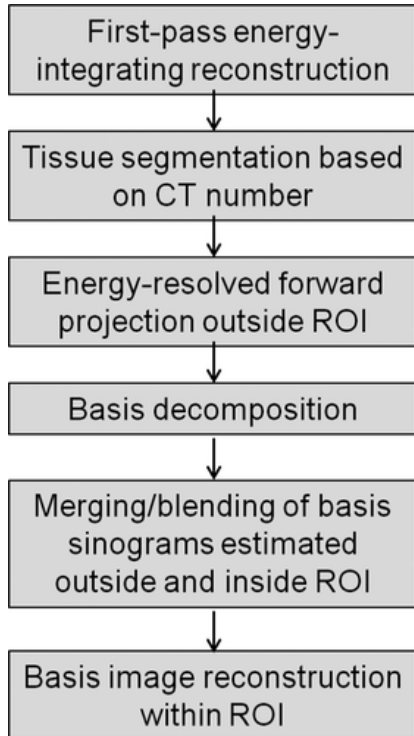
Proposed algorithm for reconstructing ROI basis images from truncated energy-resolved CT data with prior energy-integrating data.
